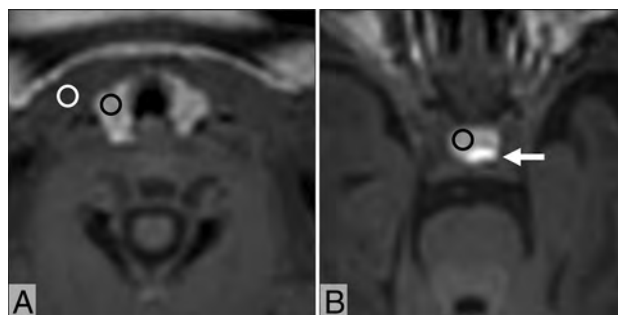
Axial 3D GRE T1-weighted MR images of an infant at postnatal day 6 show the thyroid (A) and pituitary (B). For measurement of the signal intensity, ROIs are placed on the thyroid (black circle, A), sternocleidomastoid muscle (white circle, A), and anterior pituitary (black circle, B). The posterior pituitary is shown (arrow, B).
